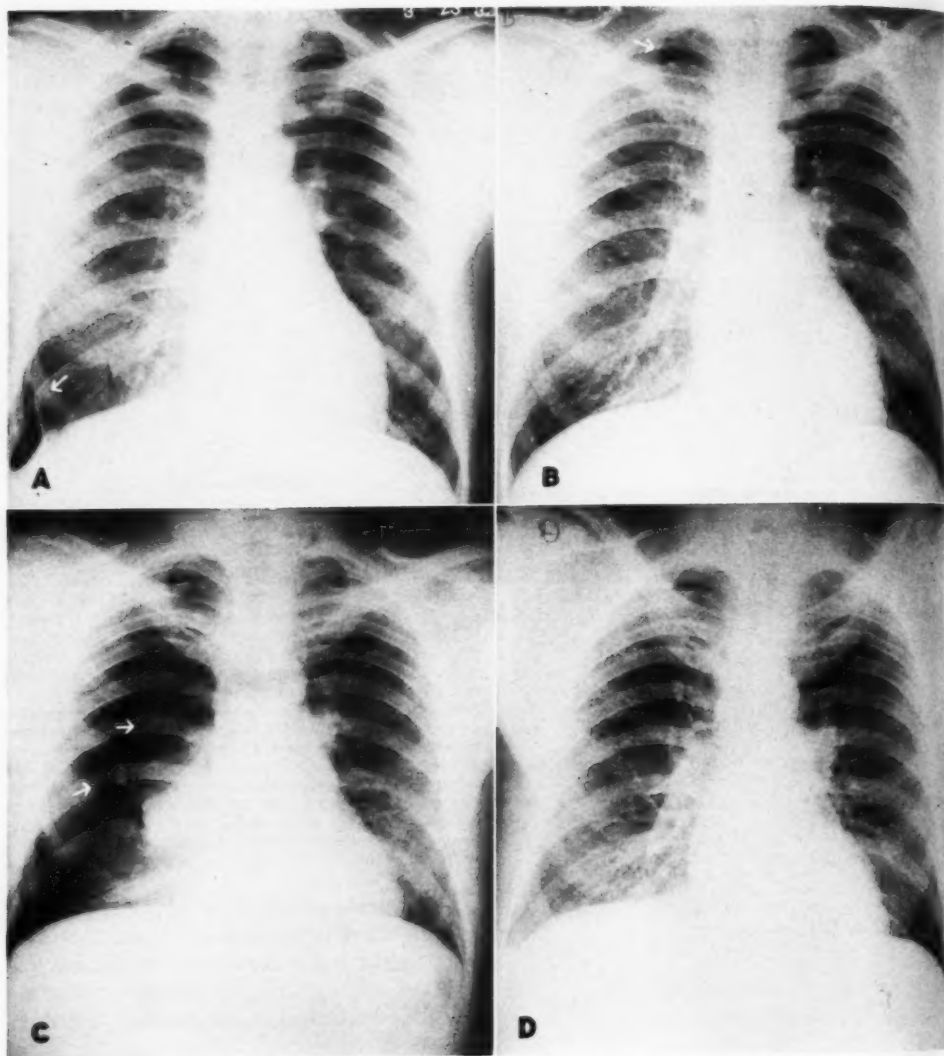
Recurrent spontaneous pneumothorax, with demonstrable bullae. A. March 23, 1932, partial pneumothorax, right. B. May 21, 1940, bullae at right apex. C. Nov. 20, 1941, recurrent pneumothorax, right, with demonstrable bullae at apex of collapsed right upper lobe. D. Jan. 12, 1942. Roentgenogram of chest, patient asymptomatic.
